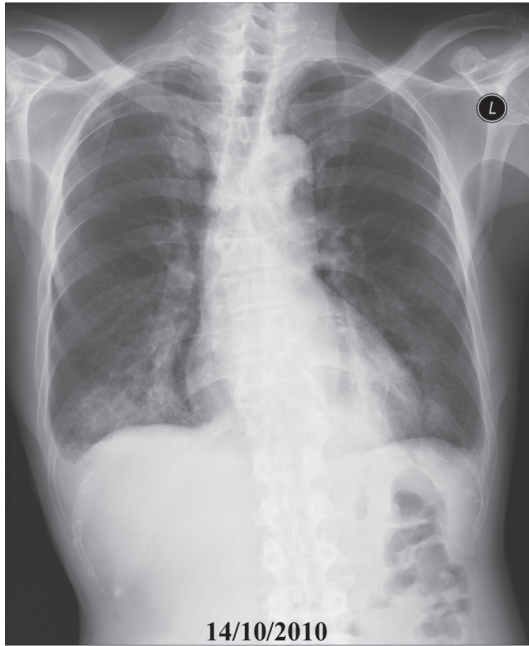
The chest x-ray shows patchy infiltration at right lower lung.
